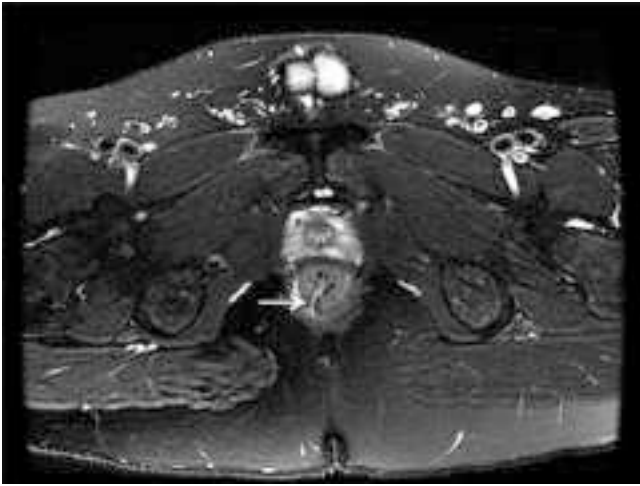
Suprasphincteric anal fistula secondary to anal trauma [magnetic resonance imaging]. White arrow points to fistula tract.
